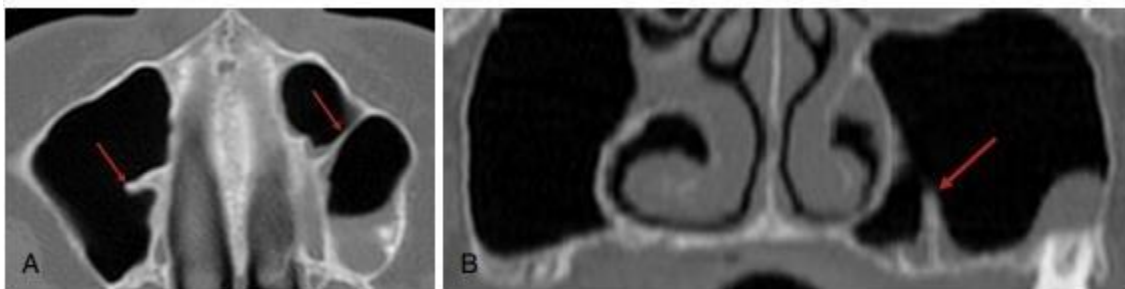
(A) Axial view dental CT scan shows a sharp osseous septa emerging from the medial wall of the right sinus cavity. A long septa completely divides the left sinus cavity into two separate compartments. (B) Panoramic view of dental CT scan showing a sharp osseous septa emerging from the floor of the left sinus cavity
